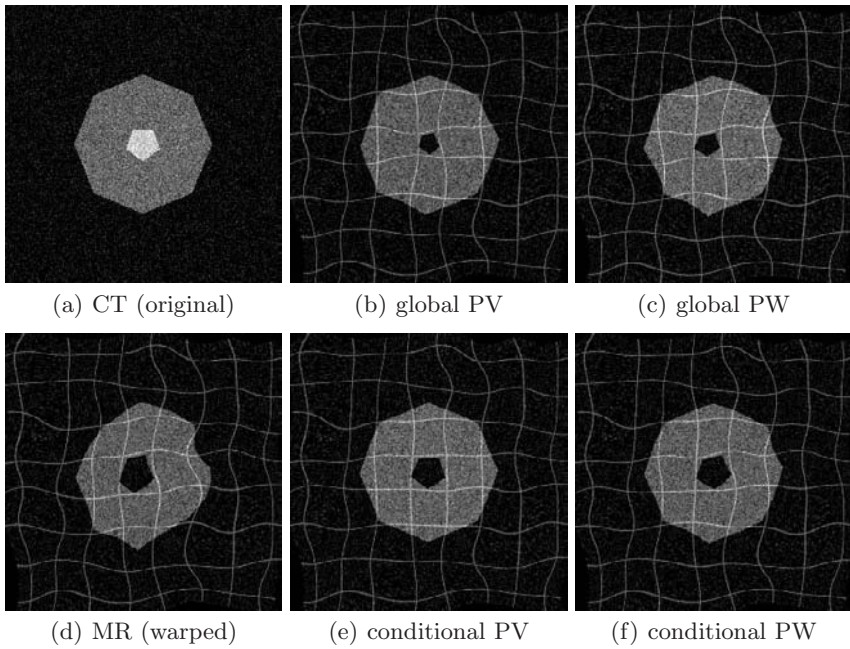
Example of the registration results obtained for CT/MR registration
